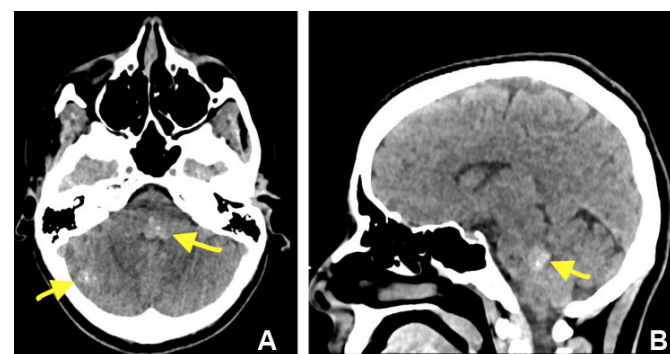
CT scan without contrast, axial, and sagittal images showing cavernoma in the left paramedian posterior pons (yellow arrows).
